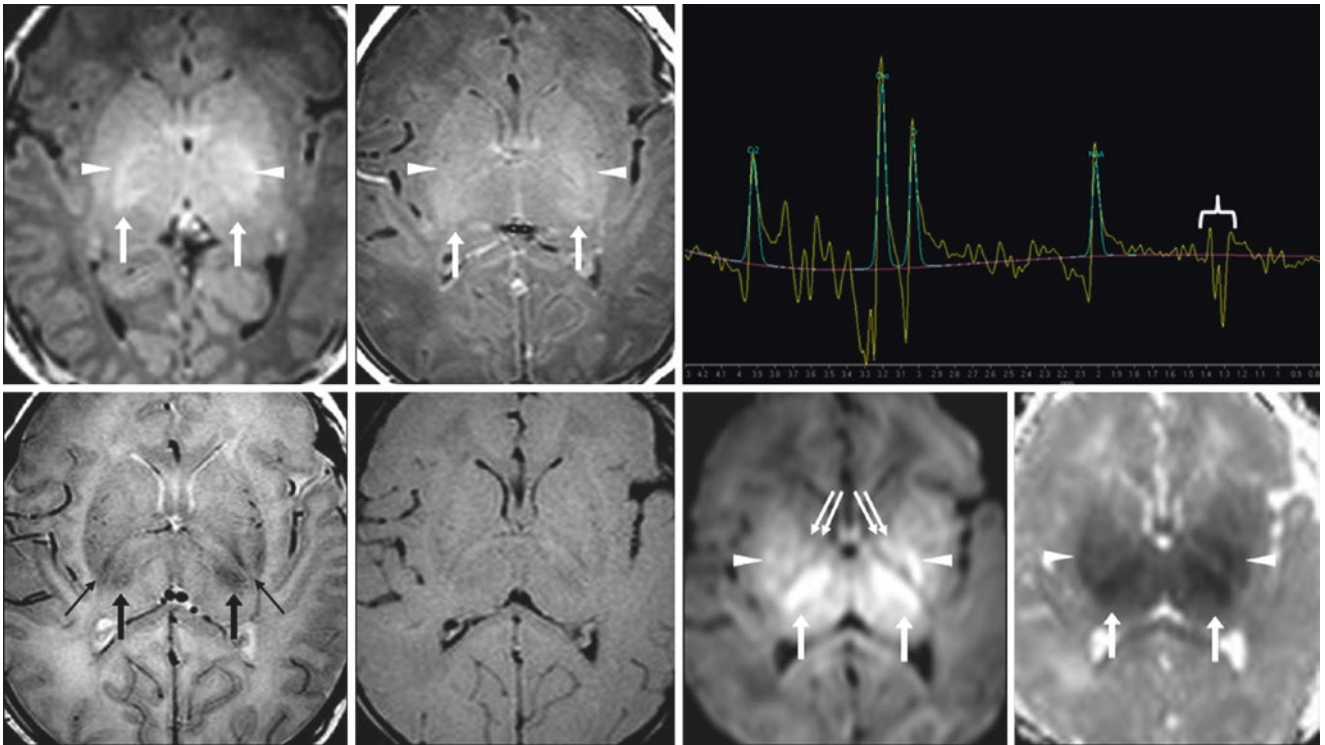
Comparison case of hypoxic-ischemic injury (HII). A 4-day-old term neonate with a hypoxic event, seizure, and an abnormal EEG had a abnormal 3T MRI, which included “blotchy” basal ganglia and globi pallidi (*double arrows*) that appeared too bright and bunched together on GE T1WI (*top left*) and SE T1WI (*top middle*).
